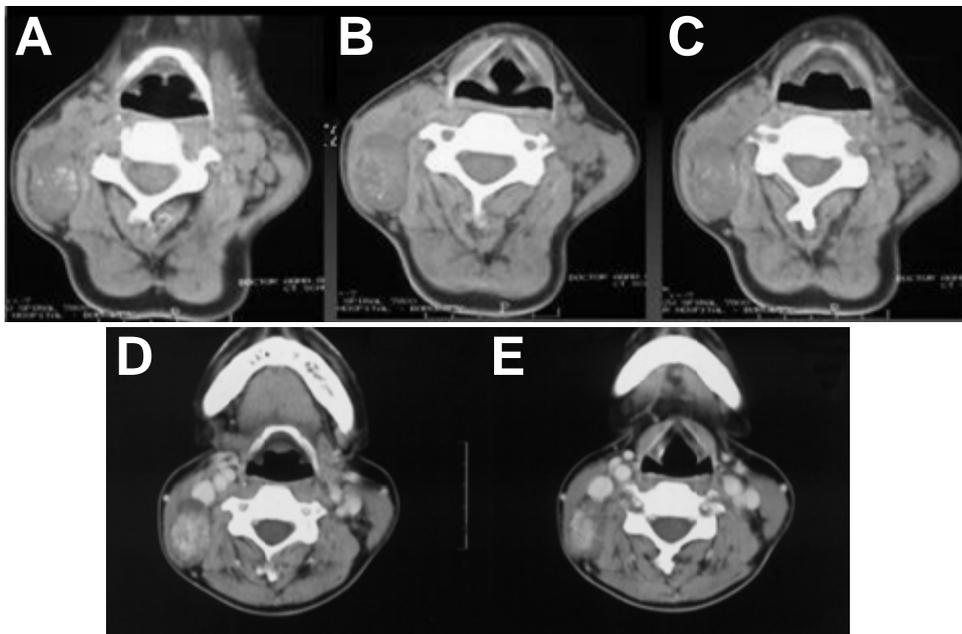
A-E. Contrast and non-contrast CT showing a partially heterogeneous enhancing mass with multiple calcified foci in the right posterior neck space which have displaced the vessels anteriorly. No surrounding fat stranding is evident.
